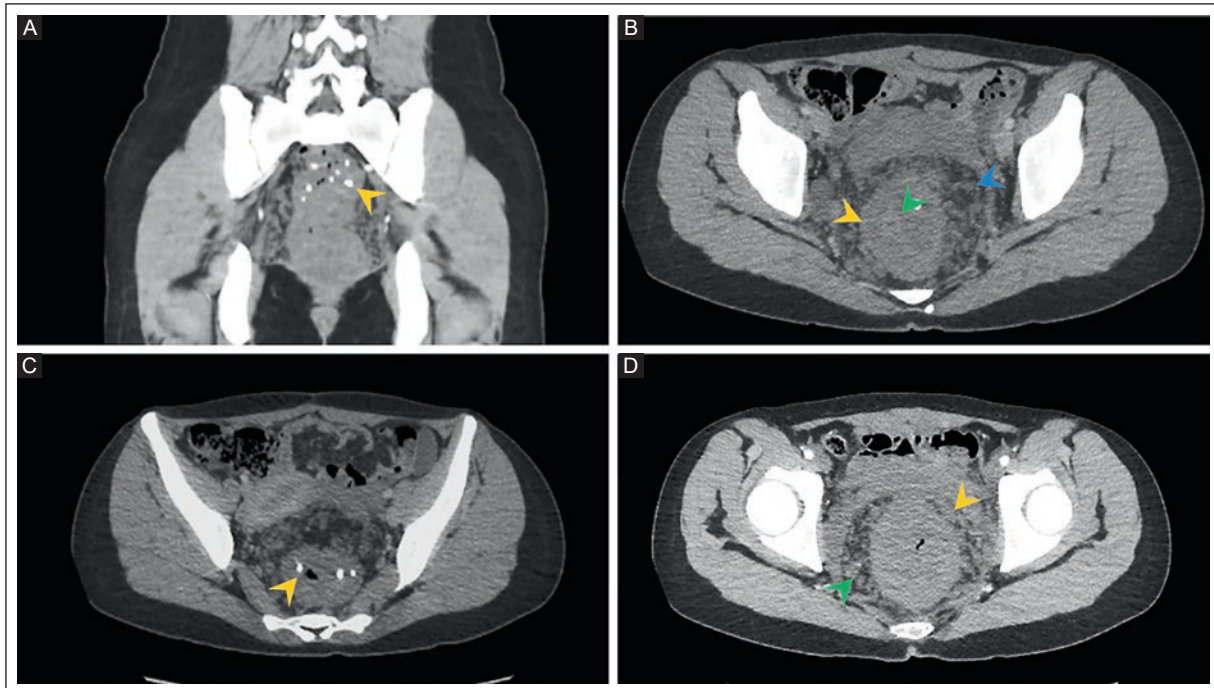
Non-contrast and contrast-enhanced abdominopelvic CT of a 20-year-old woman with intermittent hematochezia and severe anemia. A: coronal non-contrast CT image shows multiple mural phleboliths in the rectal region (orange arrowhead). B: axial contrast-enhanced venous phase CT image shows concentric rectal thickening (orange arrowhead), mild mucosal enhancement (green arrowhead), and multiple perirectal serpentine vascular structures (blue arrowhead). C: axial contrast-enhanced CT image shows phleboliths in the rectal wall (orange arrowhead). D: axial contrast-enhanced CT image shows concentric mural thickening of the rectum (orange arrowhead) and multiple perirectal serpentine vascular structures (green arrowhead).
